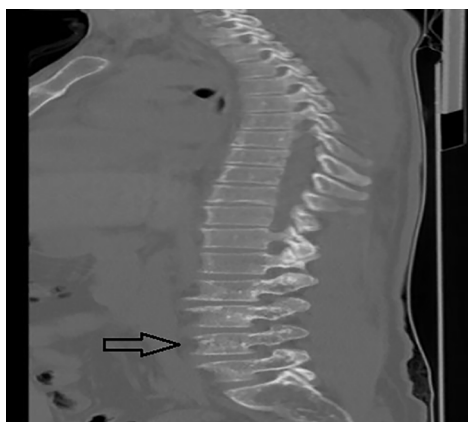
Lumbar spine radiograph with prominent sclerotic lesions in the vertebral bodies, more pronounced than in the thoracic region
